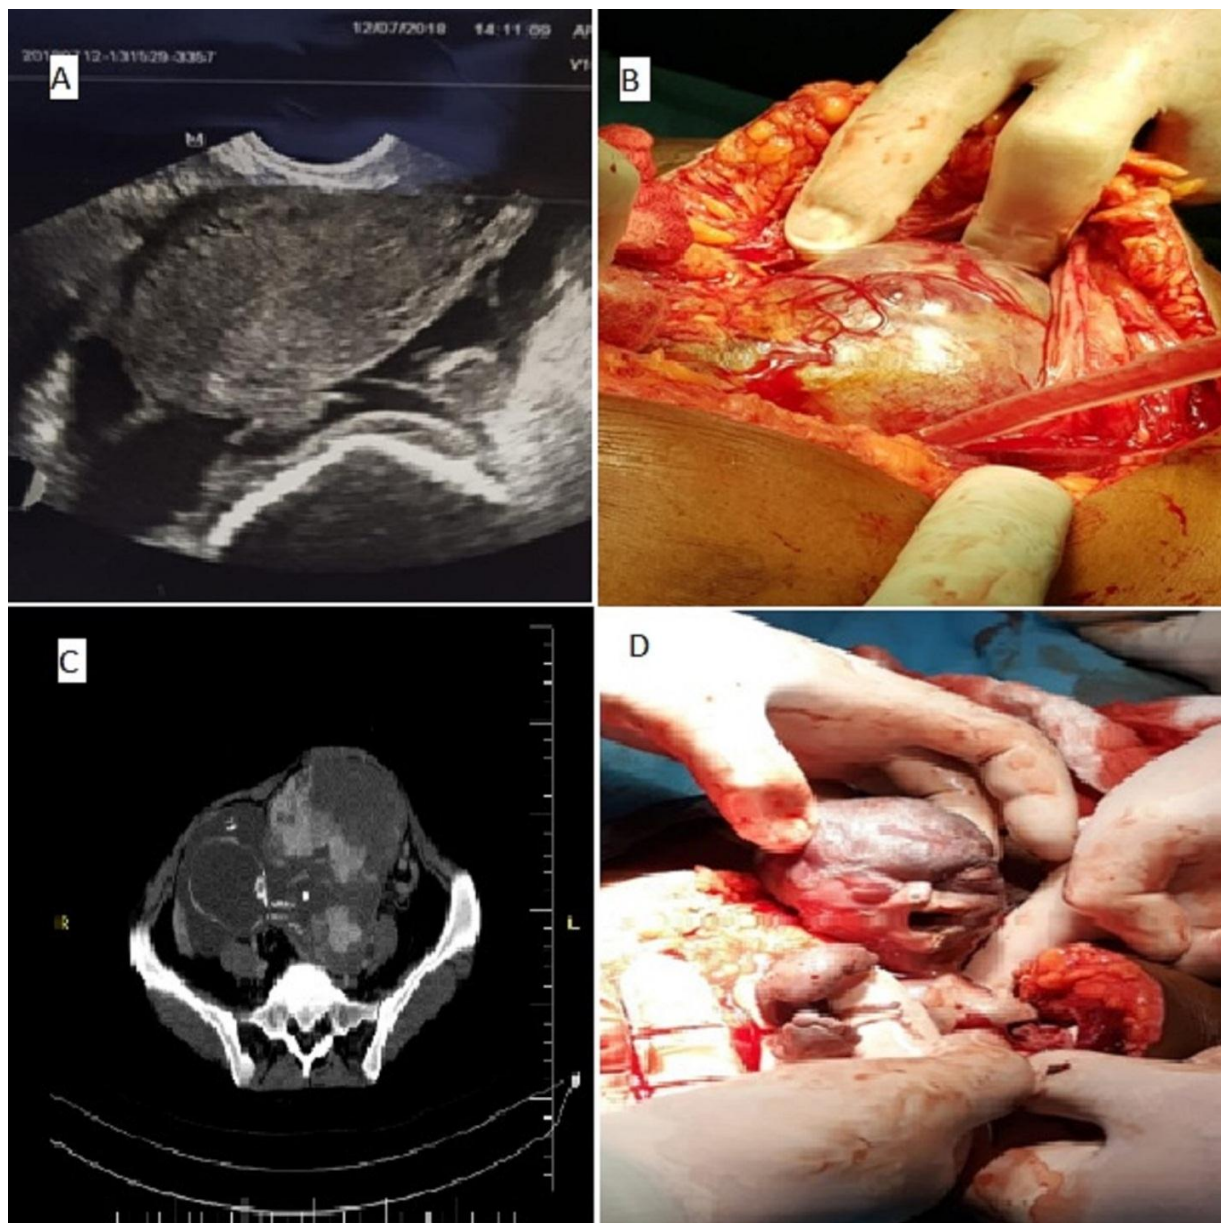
Image A shows the transvaginal ultrasound and the empty uterus in addition to ectopic pregnancy. Ultrasound, CT, and the two images of laparotomy
